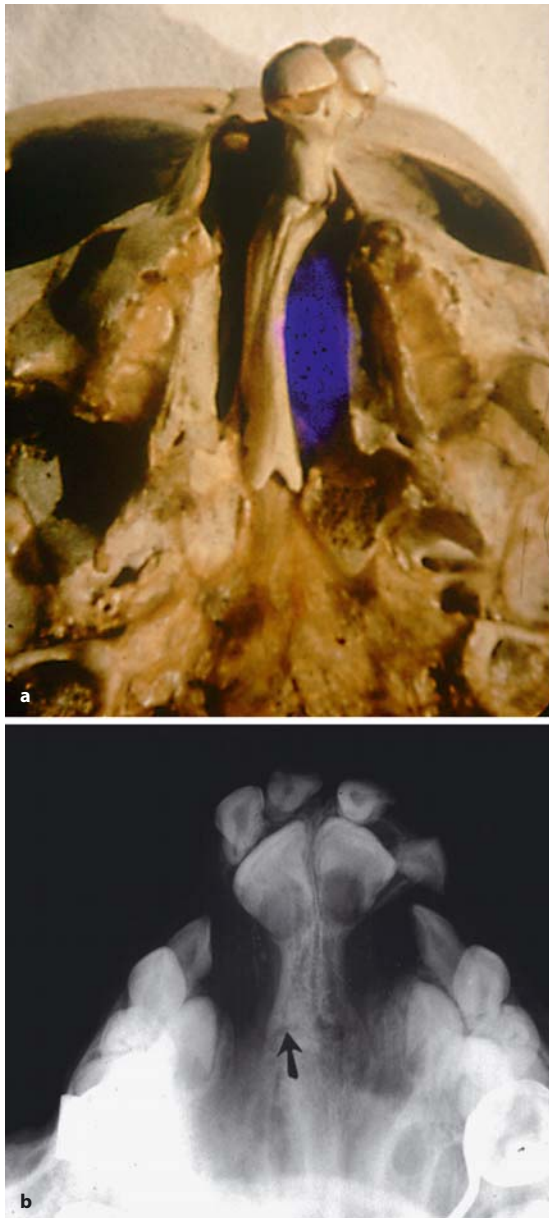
a–c. Skull with a bilateral cleft and palate. a The palatal segments have been overexpanded and the premaxilla protruded by the resultant aberrant muscle forces. The premaxillary-vomerine suture separates the premaxilla and the vomer and is a growth site. b Lateral cephalometric tracing at birth. Lines connecting various landmarks create a polygon depicting their geometric relationships. This tracing of a CBCLP at birth shows the degree of premaxillary protrusion. *S* = Sella Turcica, *N* = Nasion, α = Alpha (the anterior extent of the premaxilla), *Po* = Pogonion, *Gn* = Gnathion, *Go* = Gonion, *PVS* = Premaxillary-vomerine suture. c Occlusal radiograph of the premaxilla and vomer showing the premaxillary vomerine suture (arrow)
